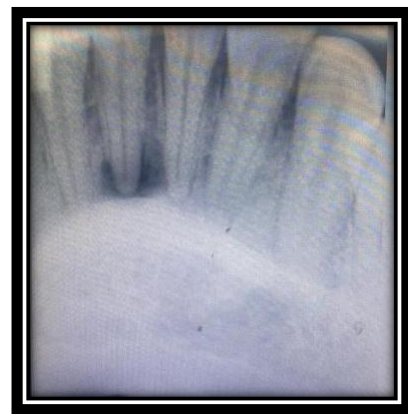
Pre-operative radiographic profile
